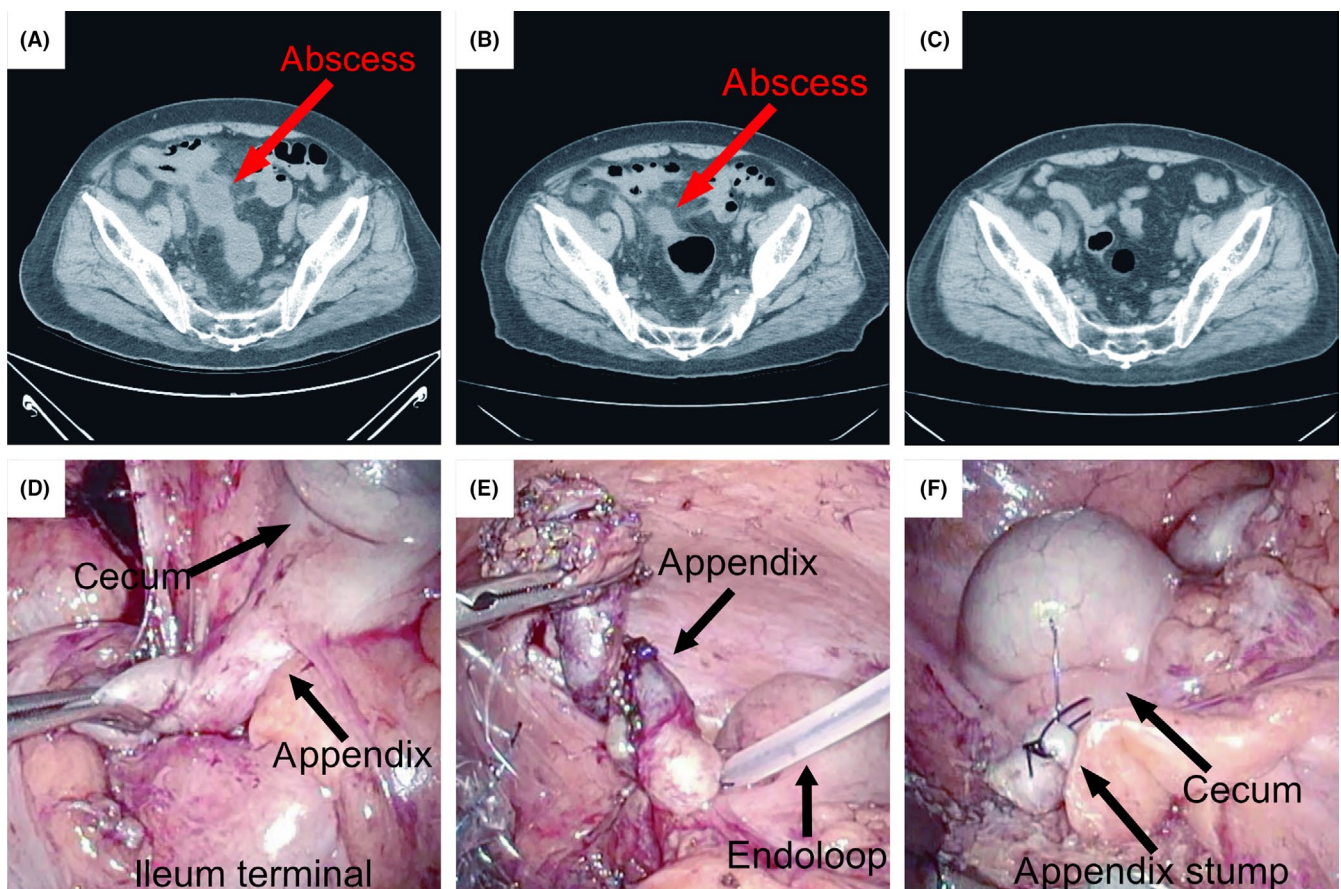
Typical treatment course of single-site laparoscopic interval appendectomy (SLIA). A, Abscess before conservative treatment (CT). (B and C) The abscess was shrinking 2 wk after CT and eradicated 3 mo after CT, just before SLIA. D, Adhesions could be peeled off safely after successful CT. (E and F) The appendix was ligated using an Endoloop (E) and resected at the radix without the embedded appendix stump (F)
